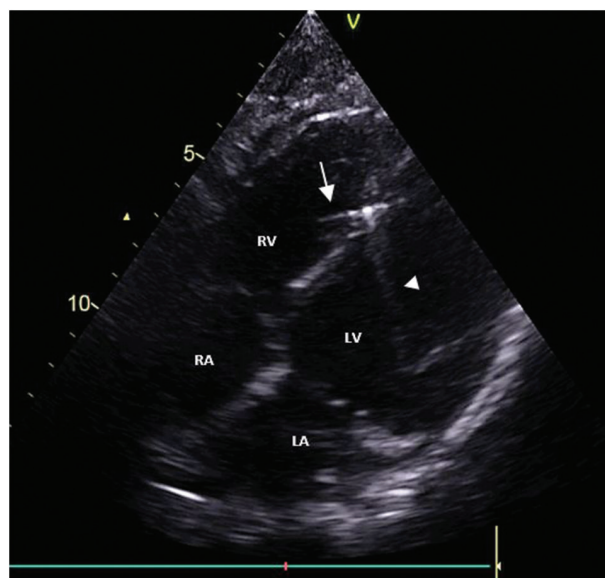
Transthoracic echocardiography demonstrating the needle (arrow) in the right ventricle (RV) and its acoustic shadow (arrow head).
